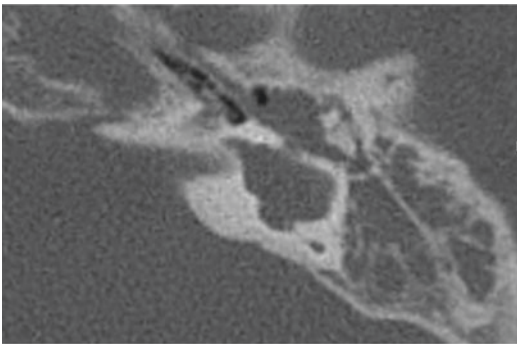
HRCT showing CC with a soft tissue mass in the middle ear on the left side
